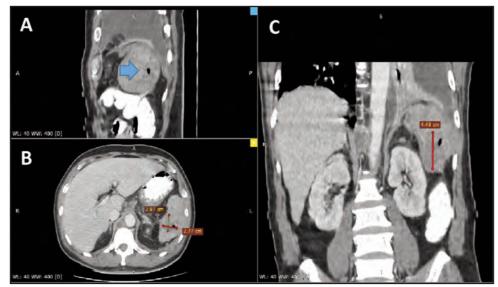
Computer tomography (CT) of abdomen done on the day 1 of presentation. This is the Multiplane Reconstruction (MPR) view showing a multiple ill-defined hypodense splenic lesions with air focus within. 2A – sagittal view, 2B – axial view, 2C – Coronal view. The largest lesion (thin arrow) measuring apporximately 3.0 x 2.8 x 4.5 cm (AP x W x CC). Thick arrow showing an air focus.
